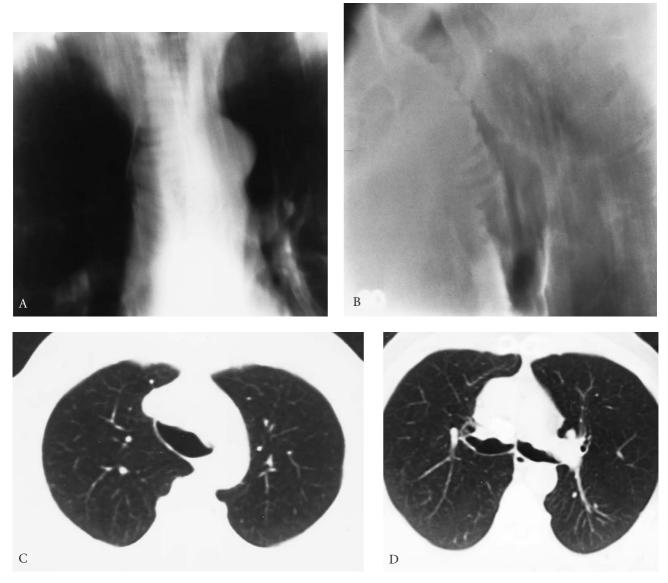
Mounier-Kuhn syndrome. Anteroposterior (A) and lateral (B) tomograms of the trachea demonstrate dilatation of the trachea and main bronchi, with a scalloped or corrugated appearance. Computed tomography scans of the midtrachea (C) and main bronchi (D) demonstrate dilated scalloped-appearing airways.
